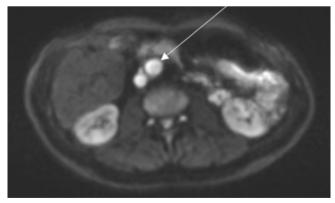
Axial DWI shows restricted diffusion of the lesion (arrow)
